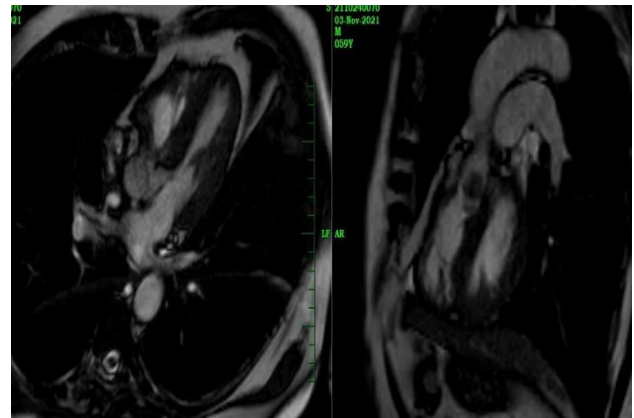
Cardiac MRI confirmed the features DCRV and ruled the absence of other associated cardiac anomalies. Demonstrated protruded right SVA's toward the right ventricle.
